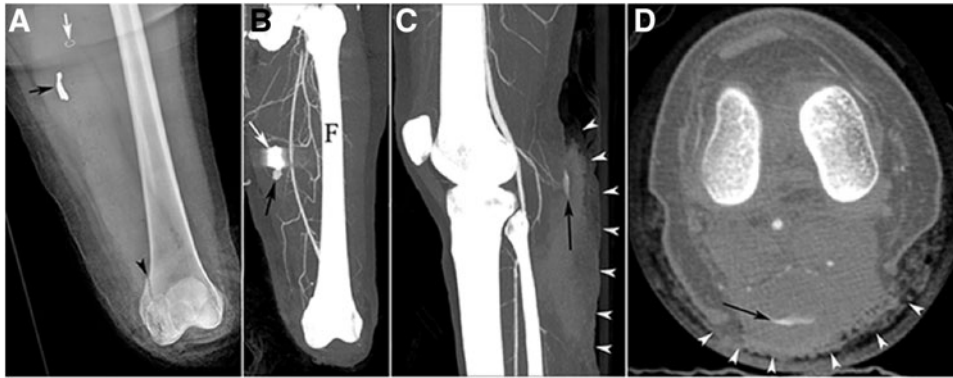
CT imaging in a patient after primary and secondary blast injuries to the lower extremities and an emergency below-the-knee amputation of the left limb. (A) Radiography postamputation identified the presence of a metallic foreign body (black arrow), surgical staple (white arrow), and distal femoral fracture (arrowhead) in the left limb. (B) A maximum intensity projection (MIP) of CT angiography revealed a pseudoaneurysm (black arrow) in the immediate proximity of shrapnel (white arrow). (C) A sagittal MIP of a CT angiogram of the right limb identified the presence of a second pseudoaneurysm (black arrow) that is also apparent in the (D) axial view, in combination with a prominent soft tissue defect on the posterior aspect of the limb (arrowheads). Reprinted with permission from Guermazi *et al.*²³ CT, computed tomography; F, femur.
